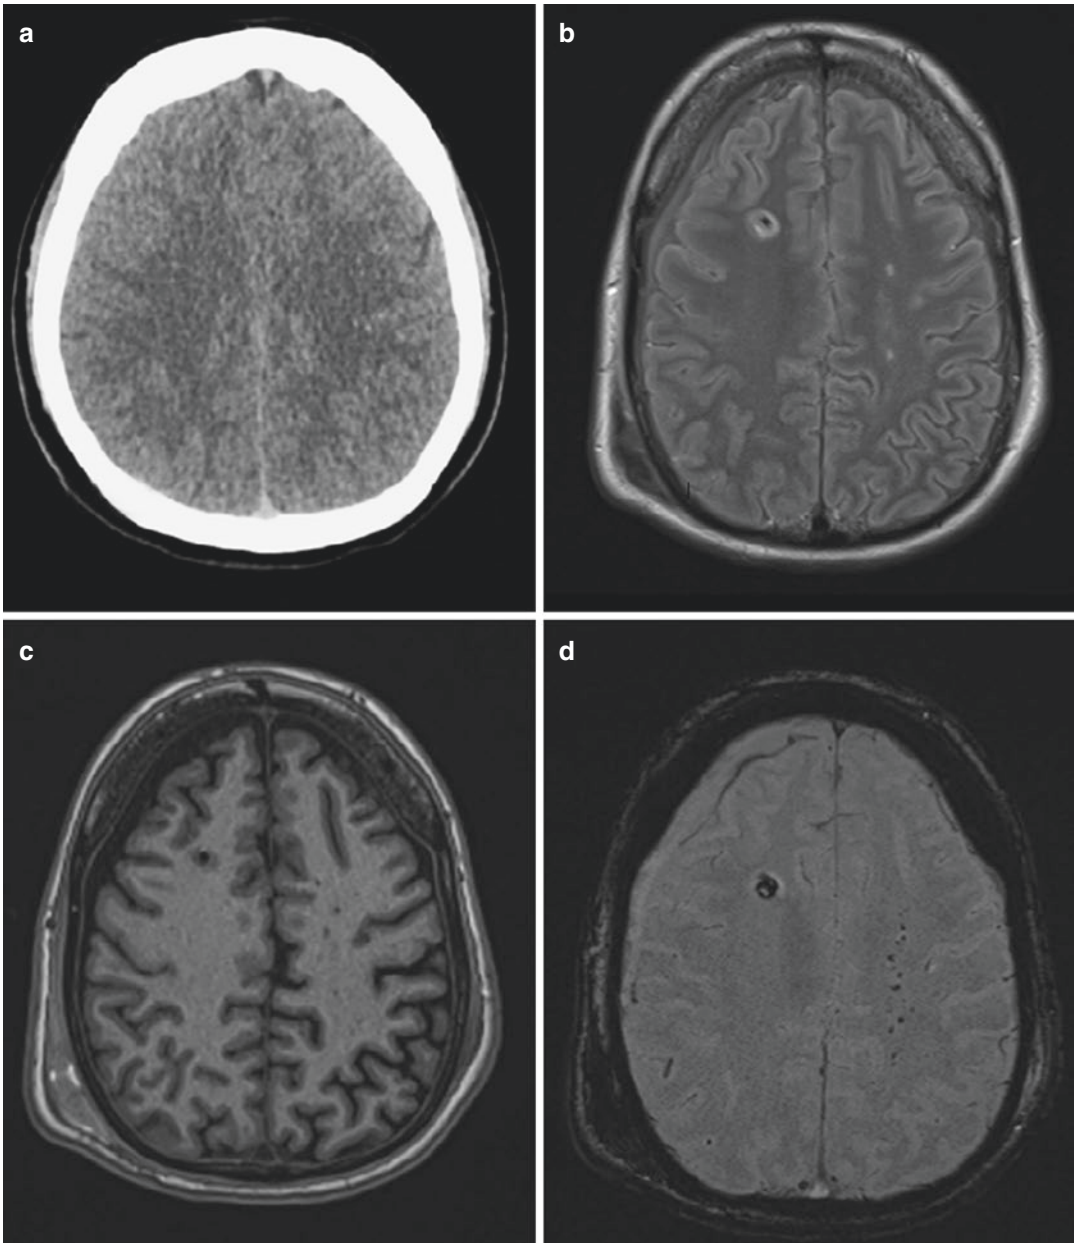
Diffuse axonal damage in cross-sectional imaging. (a) With CT, at most questionably small haemorrhages are visible frontoparietally at the marrow bark boundary on the left. (b–d) In MRI, on the other hand, the extent of the damage is more clearly shown by punctiform microbleeding, especially in the left medullary bed and partly corresponding punctiform diffusion restrictions
